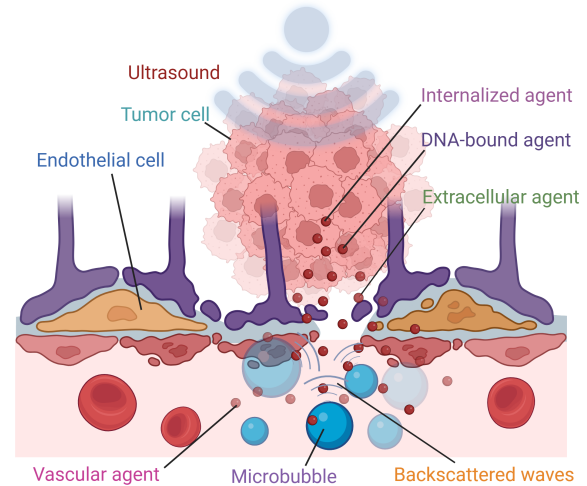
Microbubble-based focused ultrasound mechanism for BBB disruption.
